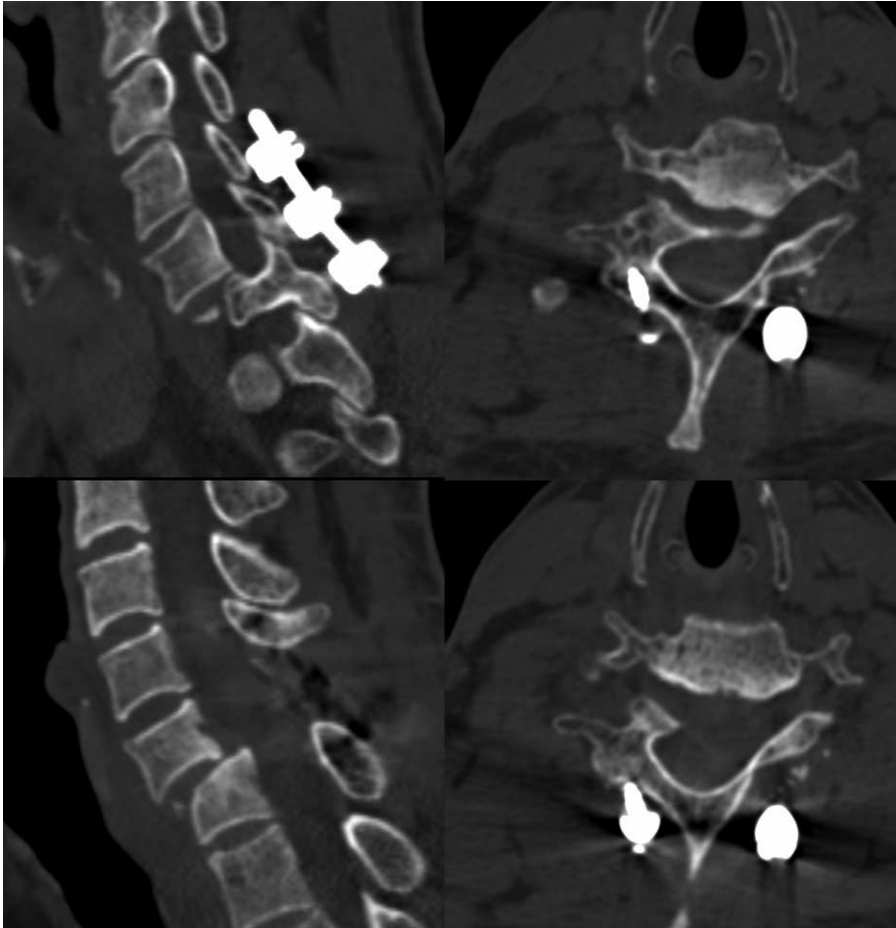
The computed tomography (CT) scan 3-dimensional reconstruction images confirmed the redislocation of C6/7 and showed the laminectomy and lateral mass screw fixation in his primary surgery.
